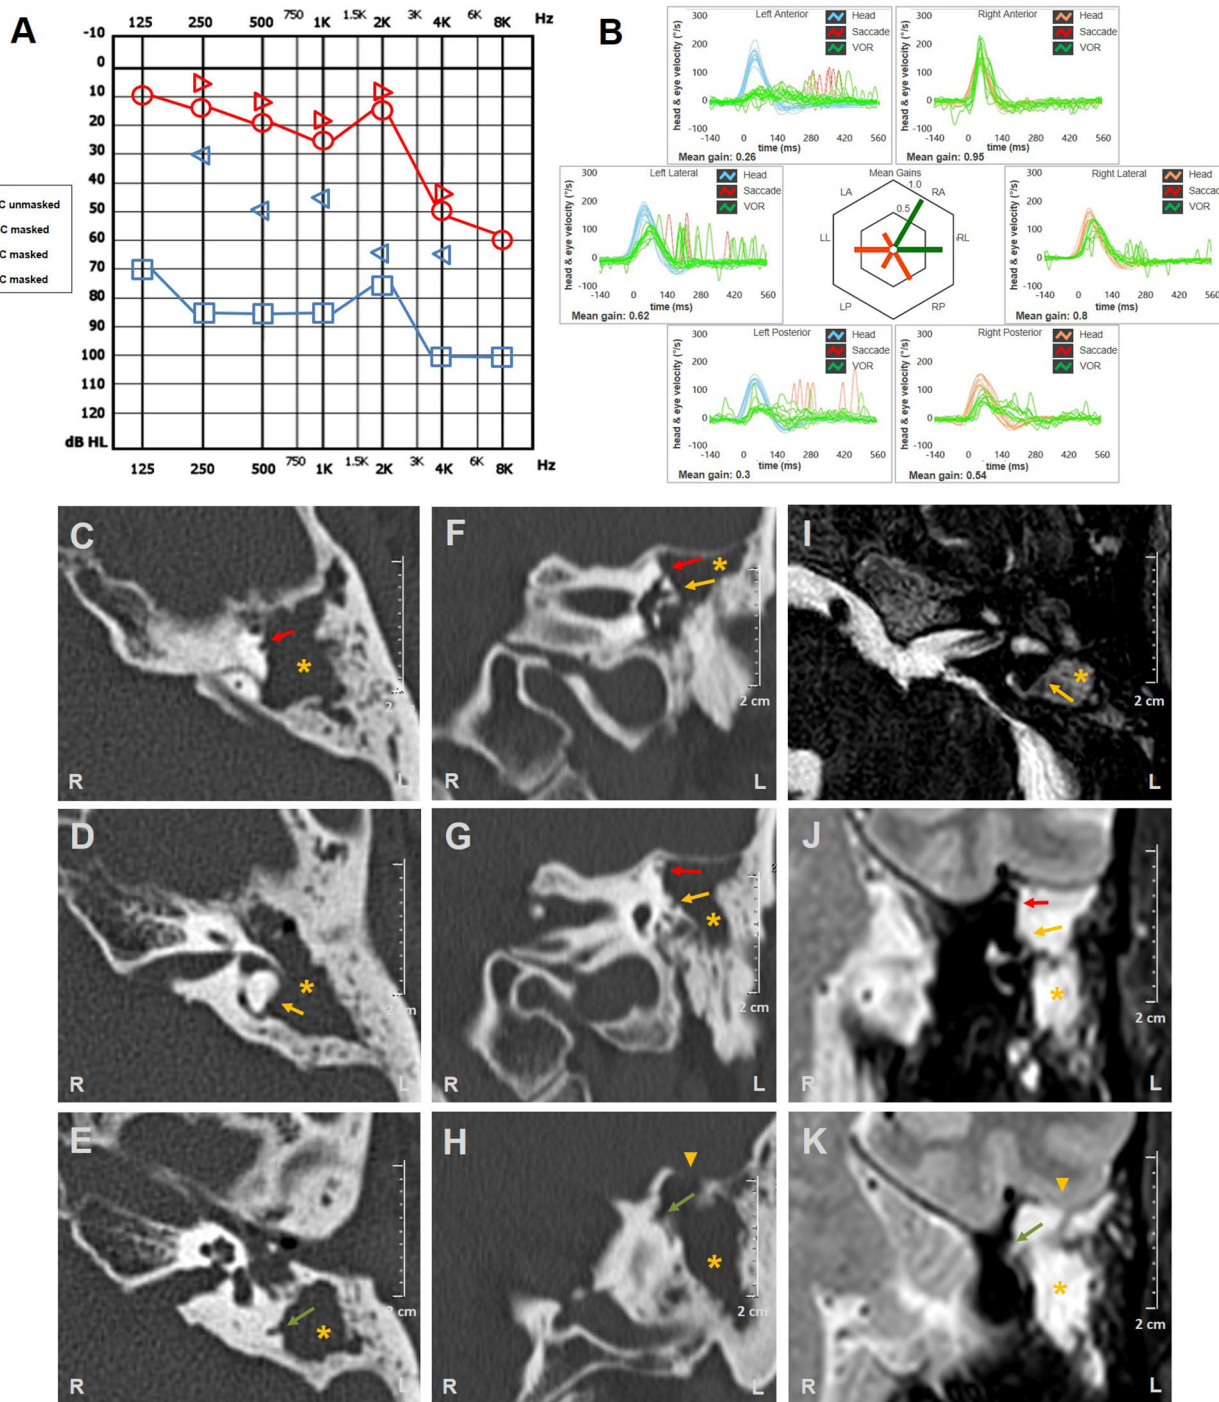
Instrumental and radiological data of case three. (A) Audiometric testing showing high-frequency sensorineural HL on the right side and left mixed HL with significant ABG widened for low frequencies and mild-to-moderate down-sloping sensorineural hearing impairment. (B) vHIT detecting reduced VOR-gain values for all left SCs with overt saccades and slight hypofunction for contralateral PSC with no corrective saccades. Axial (C–E) and coronal (F–H) temporal bones CT scans completed with axial (I) and coronal (J,K) T2-weighted gadolinium-enhanced brain MRI showing soft tissue density (yellow asterisks) within left middle-ear and mastoid cavity eroding ossicles and tegmen tympani (yellow arrowheads). Bony labyrinthine erosions of left SSC (red arrows), HSC (yellow arrows), and PSC (green arrows) are highlighted. ABG, air-bone gap; AC, air conduction; BC, bone conduction; CT, computed tomography; HL, hearing loss; HSC, horizontal semicircular canal; L, left; LA, left anterior; LL, left lateral; LP, left posterior; MRI, magnetic resonance imaging; PSC, posterior semicircular canal; R, right; RA, right anterior; RL, right lateral; RP, right posterior; SC, semicircular canal; SSC, superior semicircular canal; vHIT, video head impulse test; VOR, vestibulo-ocular reflex.
